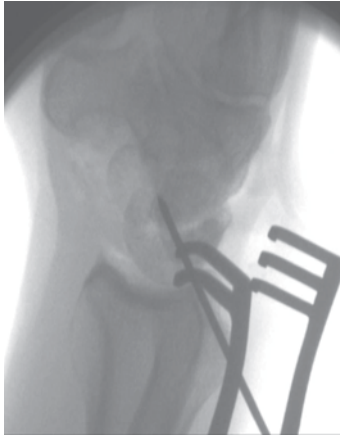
Lateral X-ray demonstrating a K-wire having been advanced across the radiolunate and midcarpal joint to attain and maintain proper lunocapitate angle. (Published with kind permission of ©R. Glenn Gaston, 2015. All Rights Reserved)
